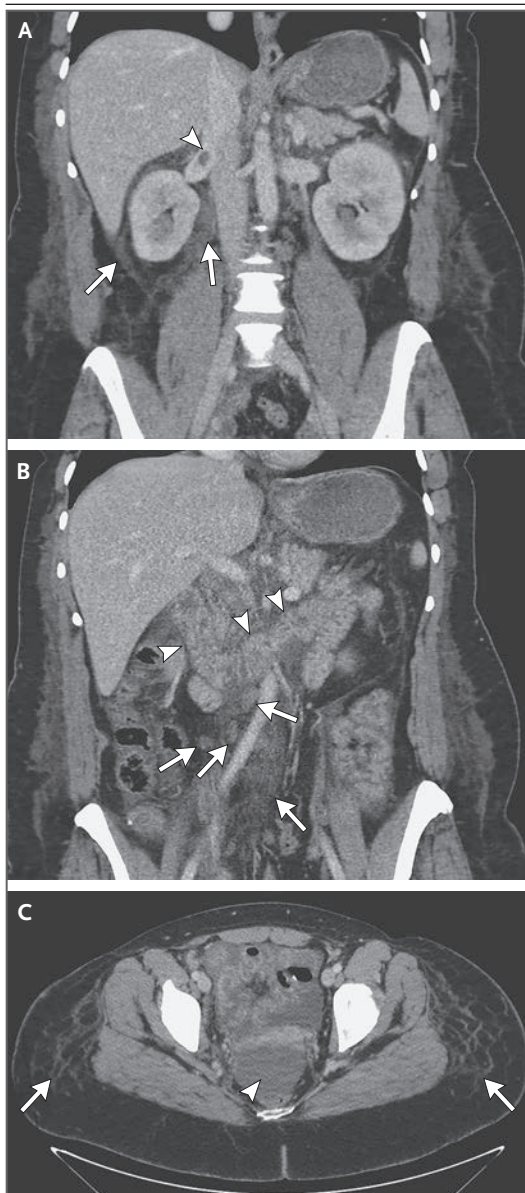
CT Scan of the Abdomen and Pelvis.
